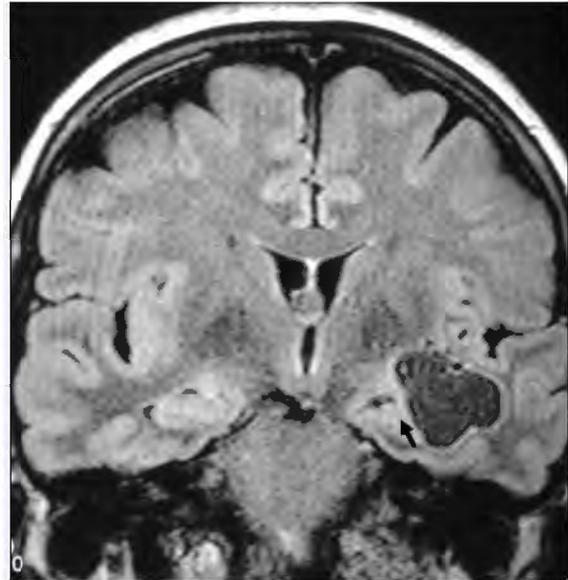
Coronal FLAIR sequence; dilated giant PVS is seen which has generated a compression effect over the hippocampal region at the lateral side of the left temporal lobe.
